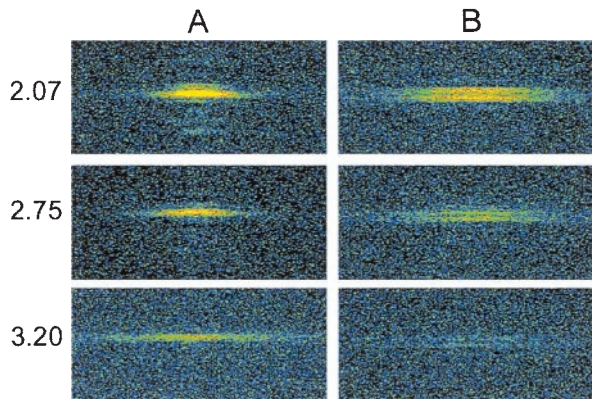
Sarcomere length-dependence of the M3 reflection at rest (A) and at the plateau of an isometric tetanus (B). Top two rows (sarcomere lengths 2.07 and 2.75 μm) are from the same fiber; Bottom row is from another fiber, sarcomere length 3.20 μm . X-ray exposure, 6 s. Each panel is $1/65 \text{ nm}^{-1}$ vertically and $\pm 1/57 \text{ nm}^{-1}$ horizontally.
